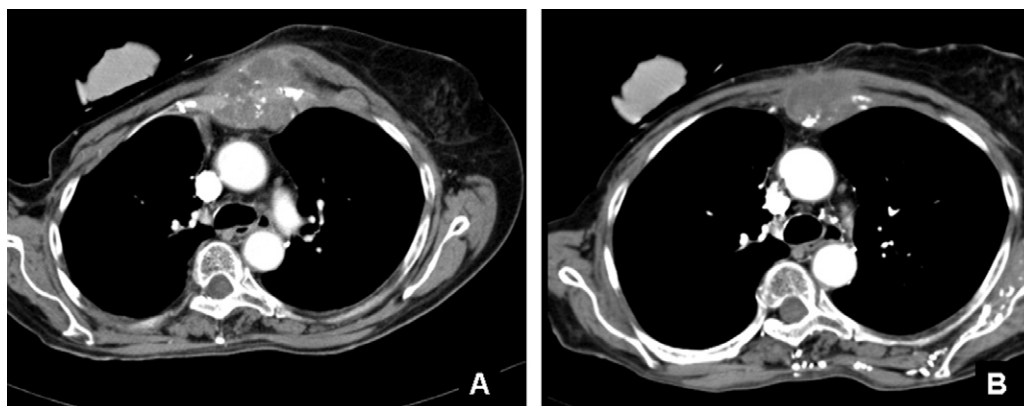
Thoracic CT-scans of a patient with radiation-induced sarcoma of the sternum before initiation of oral CPM (panel A), and after 6 months of treatment (panel B) showing a partial response.
